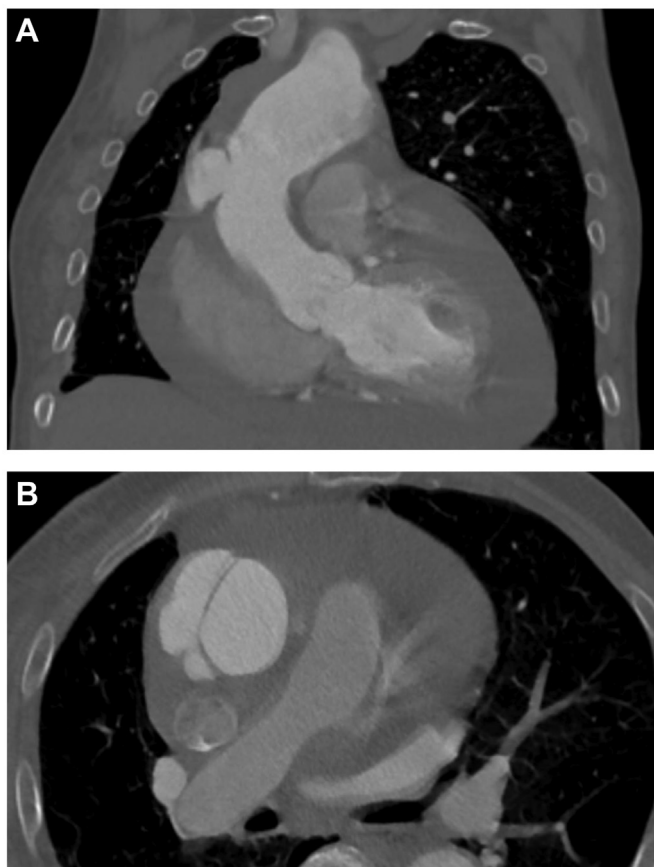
(A) Coronal and (B) axial preoperative computed tomography angiogram (CTA) displaying a ruptured pseudoaneurysm in the proximal ascending aorta (AA).
